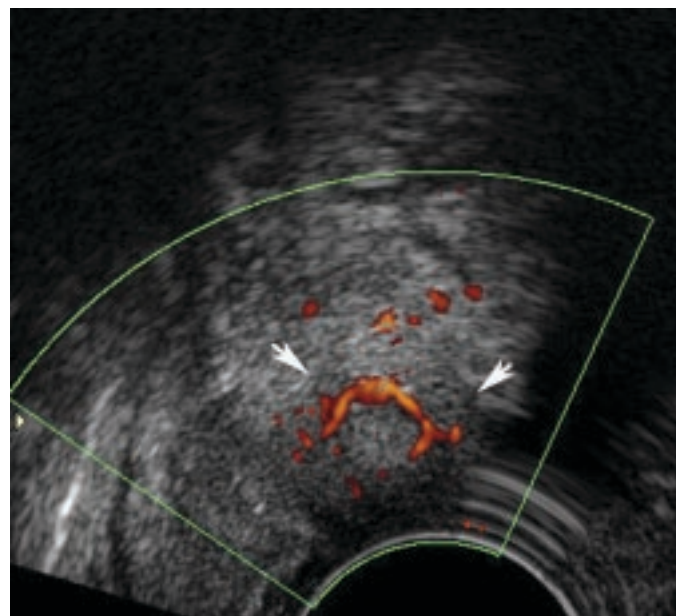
Doppler flow study reveals vascularity within the tumor (arrows).
